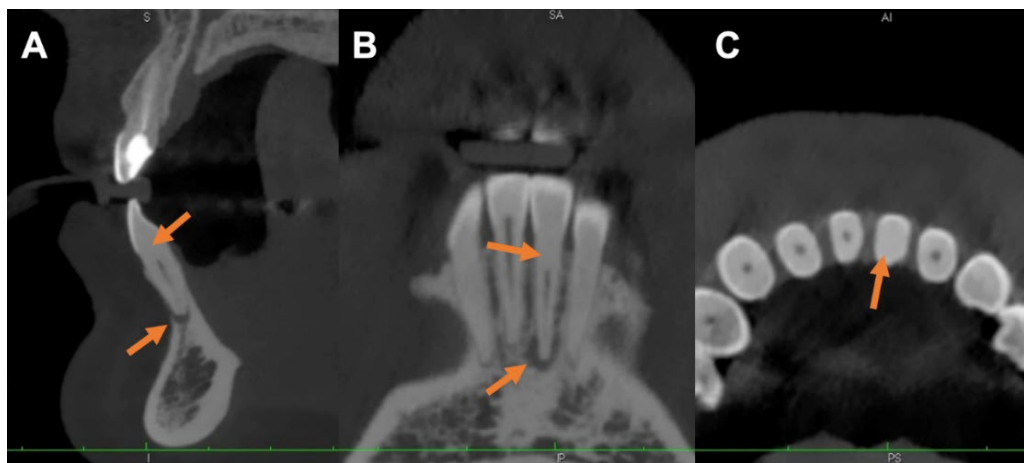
Dynamic CBCT analysis to detect calcification and presence of periapical reaction; A) Transaxial plane analysis showing calcification and the presence of periapical reaction; B) Coronal plane analysis showing severe calcification up to the middle third of the root canal and the presence of periapical reaction; C) Axial plane analysis showing the presence of severe calcification of the root canal
